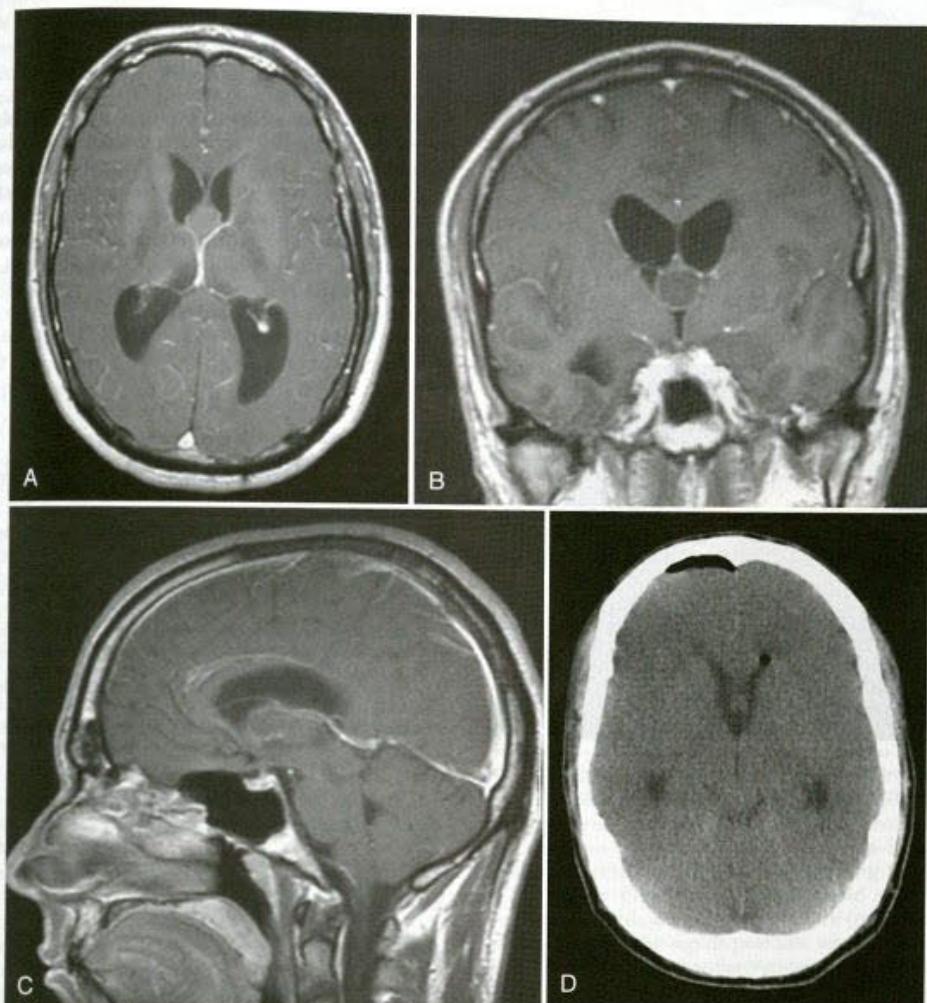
Preoperative contrast-enhanced T1 MRI showing colloid cyst obstructing both foramina of Monro. A, Axial image. B, Coronal image. C, Sagittal image. D, Postoperative computed tomography after ventriculoscopic resection through a right precoronal bur hole.
